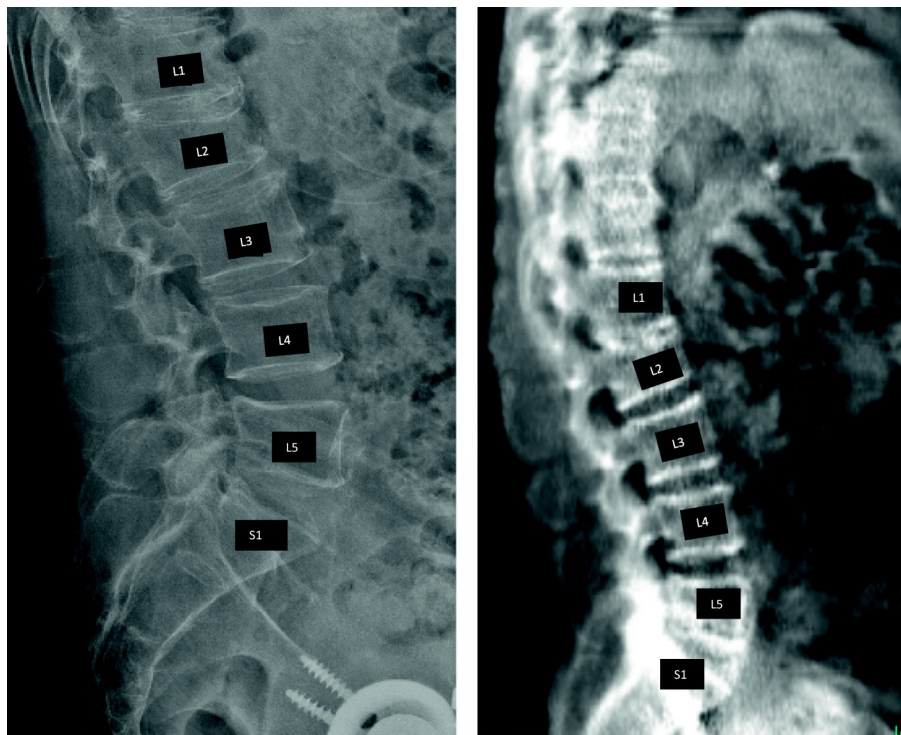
Obliquity with spine radiography. On the left, a lumbar spine radiograph demonstrates a grade 2 wedge fracture of L2. The cone beams used to create the image hit the spine at an angle, resulting in the appearance of oval, rather than parallel endplates. On the right, VFA obtained on the same patient demonstrates the same L2 fracture but with less obliquity and an enhanced view of the lumbar spine. Also seen on the VFA are hepatobiliary and intestinal shadows.
